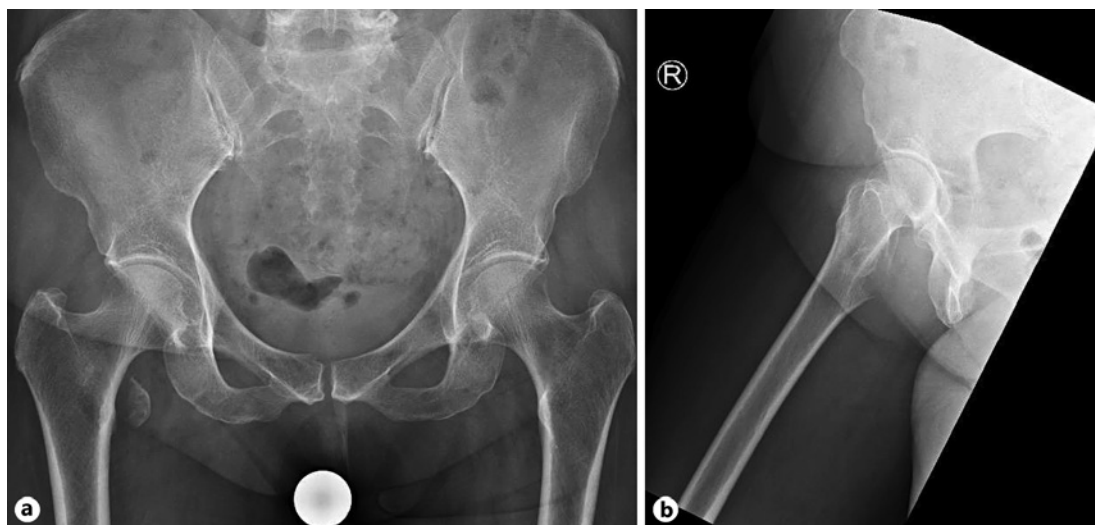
X-ray of the pelvis and lateral view of the hip showing avulsion fracture of the lesser trochanter.
